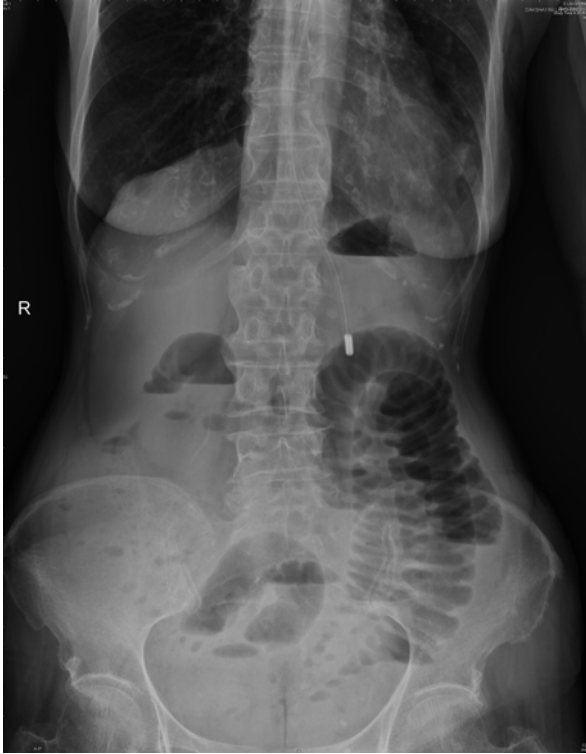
X-ray of the abdomen showing dilated small bowel loops with valvulae conniventes and multiple air fluid levels suggestive of small bowel obstruction
